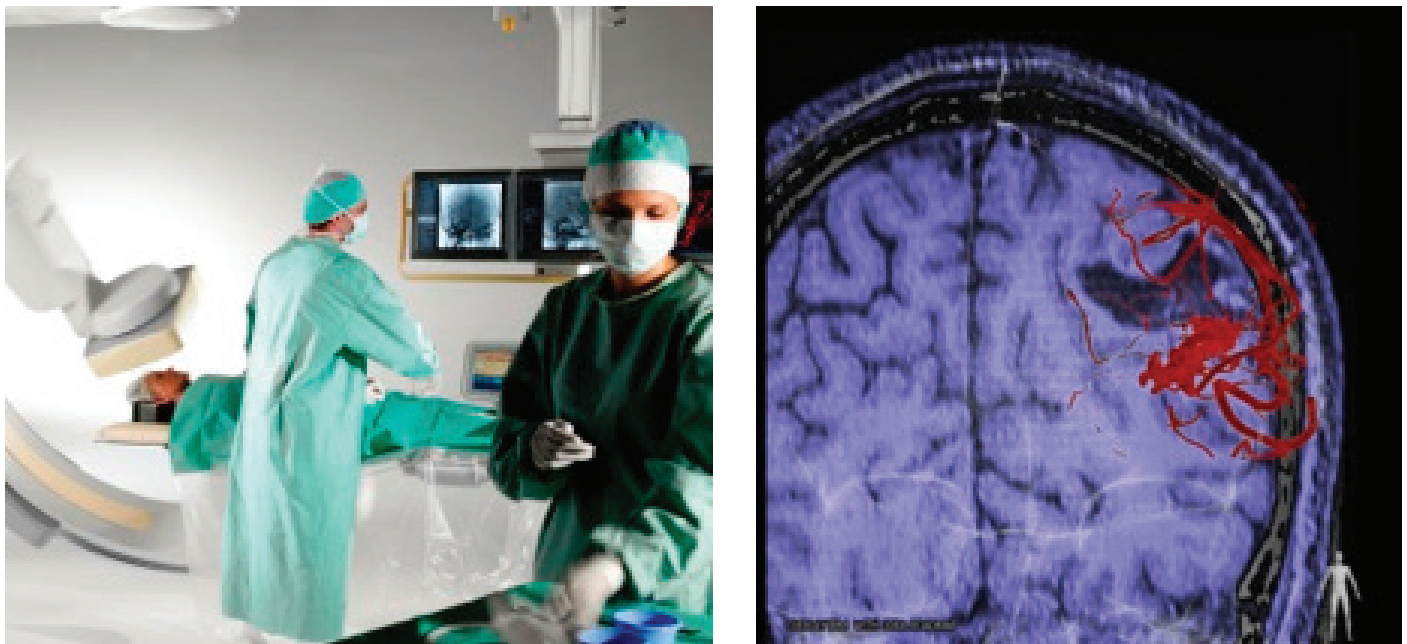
X-ray system acquires 3D volume to visualize the vessels (see red). In this example, it is than overlaid on a MRI scan that the patient had earlier (see purple).
